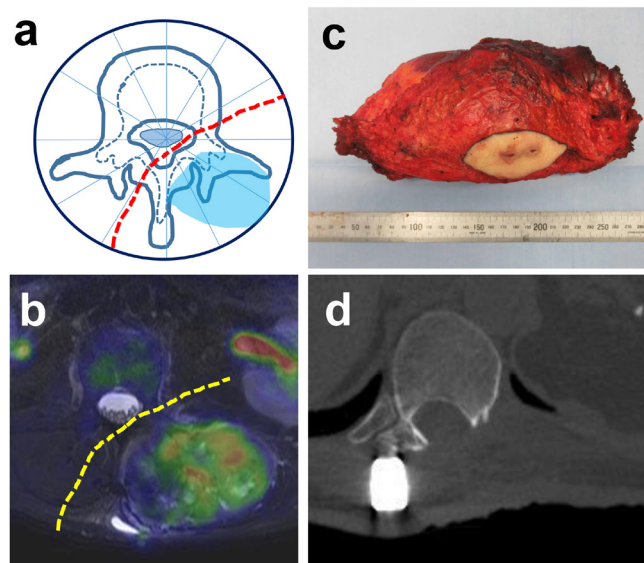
Representative case of posterior resection. (a) A 57-year-old male with dedifferentiated liposarcoma arising from the paraspinal region of the lumbar spine, with tumors present in WBB1-3, layers A, B, and C, (b) Axial T2-weighted fat-suppressed MRI image. Dashed lines indicate the planned resection line. (c) Macroscopic view of resected tumor. (d) Postoperative axial CT image.
